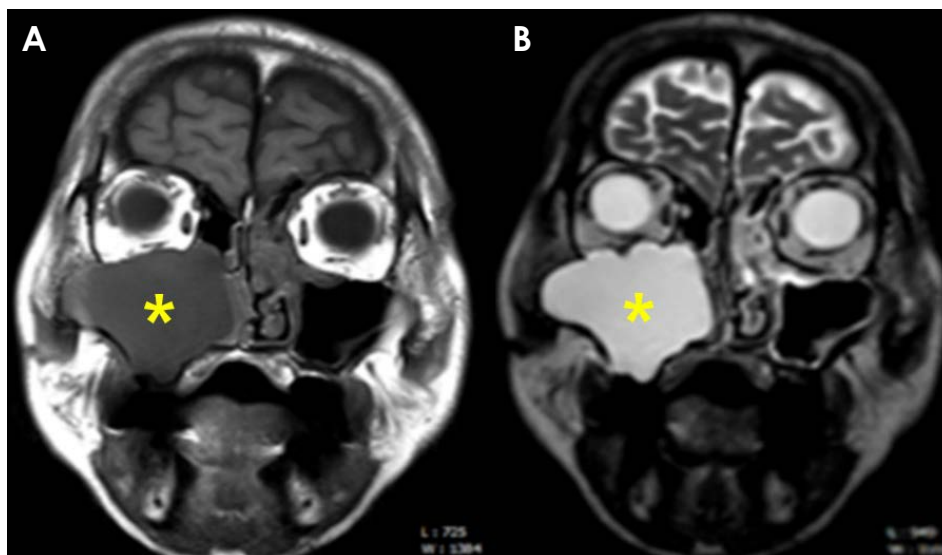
Magnetic resonance imaging shows a well-defined homogeneous lesion in the right maxillary sinus (asterisk). A. A T1-weighted magnetic resonance image shows an expansile hypointense lesion. B. A T2-weighted magnetic resonance image shows hyperintensity of the lesion. Marginal lobulation can be observed on the superior and inferior borders of the cystic lesion. A slight upward displacement of the eyeball can be observed.
